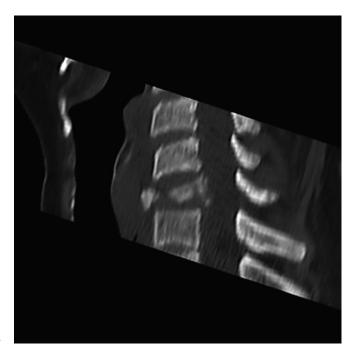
Computed tomography (CT) of breast cancer metastasis at the C6 level in a 50-year-old patient.
